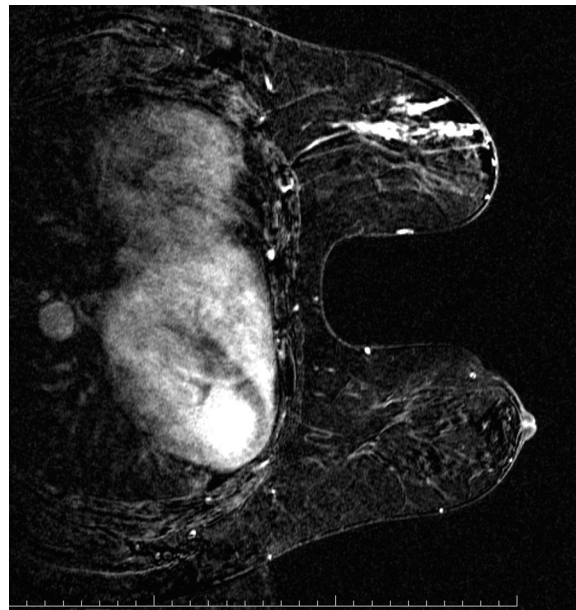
Magnetic resonance imaging demonstrating breast cancer in the right breast.
